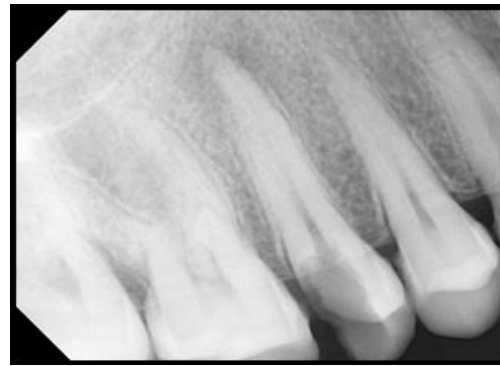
Pre-operative radiograph of #25
